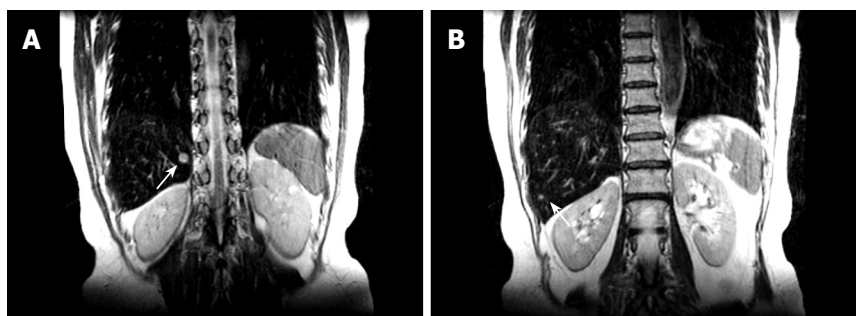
Superparamagnetic iron oxide-enhanced MRI showing hyperintense nodules. A: 10 mm nodule in segment 7; B: 4 mm nodule in segment 6.
